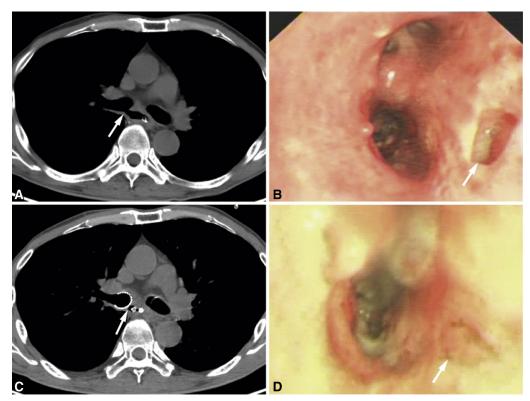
A 51-year-old man who underwent airway stenting twice. A, Axial CT image before the first stenting showed that the right main bronchus communicated with the thoracic stomach (*white arrow*). B, The stent was removed due to severe granulation tissue proliferation 62 days after the first stenting. Bronchoscopy immediately after stent removal showed that the fistula located at the posterior wall of the right main bronchus was not cured (*white arrow*). C, Axial CT image immediately after the second stenting procedure showed that the fistula was completely sealed (*white arrow*). D, The stent was removed 69 days after the second stenting. Bronchoscopy immediately after the second stent removal showed complete cured fistulas (*white arrow*).
